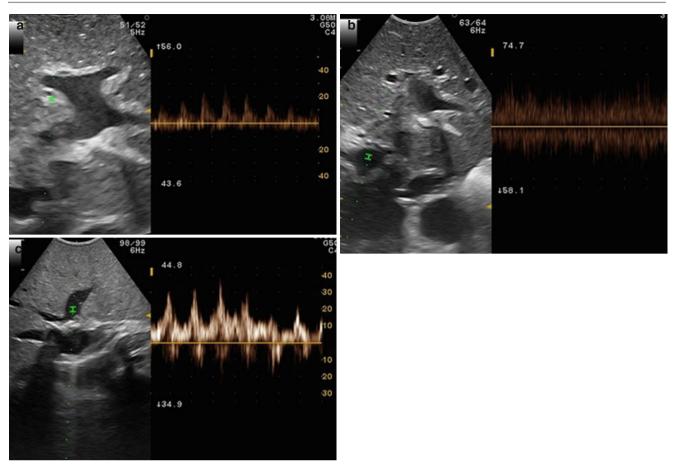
Intraoperative ultrasound during liver transplantation. Each vessel is evaluated using Doppler in this series of figures. (a) The arterial flow, (b) portal flow, and (c) hepatic venous flow
